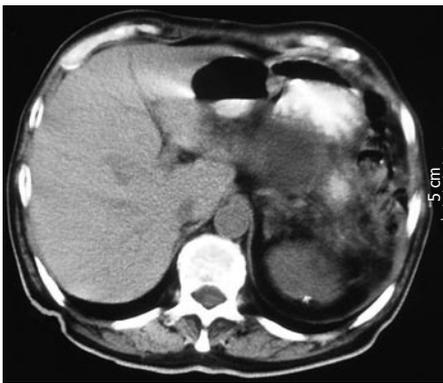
An irregular mass (5 cm in diameter) corresponding to gastric metastasis, several para-aortic lymphadenopathies and liver metastatic nodules as shown by CT scan of the abdomen.
